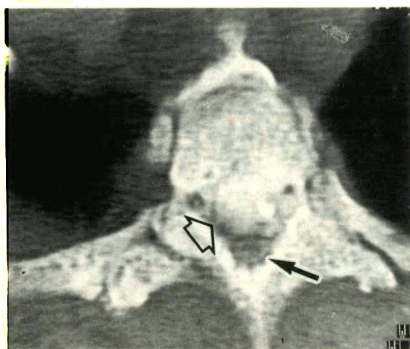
Axial CT scan of the superior thoracic level. Note the large amount of calcification in the region of the posterior longitudinal ligament (open arrow) and the compressed cord and opacified subarachnoid space (arrow). There is a small amount of residual Pantopaque.
